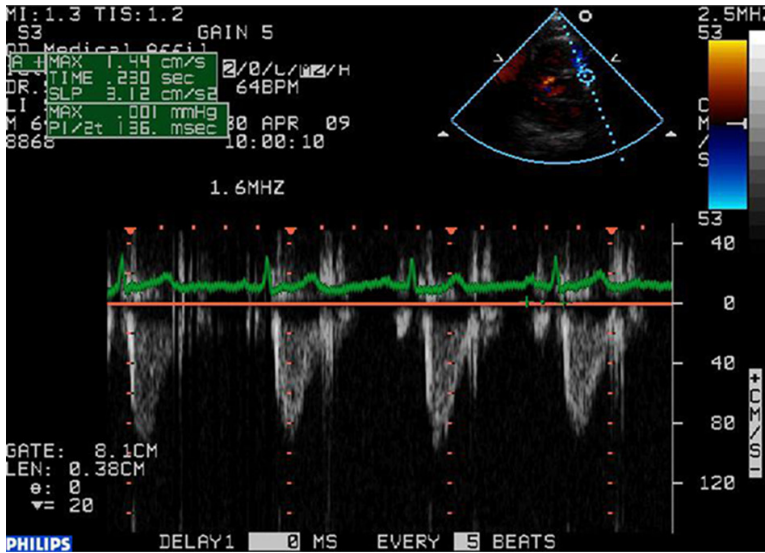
Doppler echocardiography: right ventricular ejection time.
